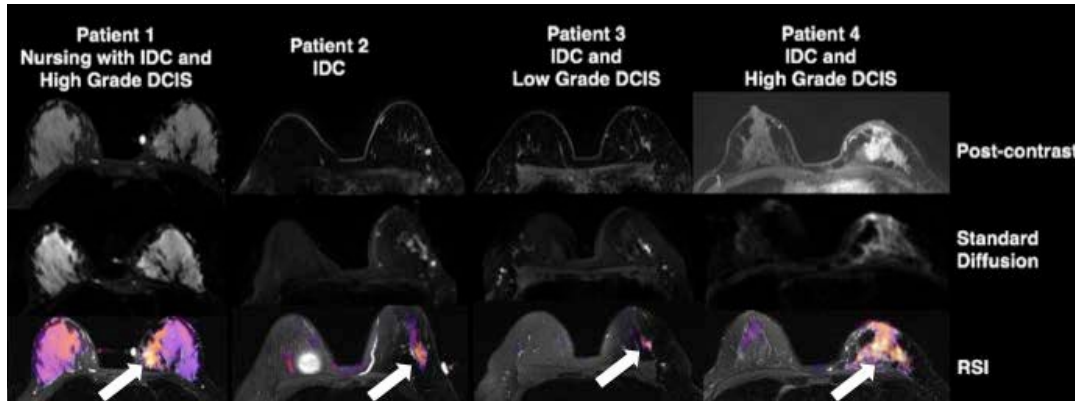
RSI detection of breast cancer. Images from post-contrast MRI, standard DWI, and RSI from 4 of 11 patients are shown. RSI-CI maps show increased tumor conspicuity in all patients in the region corresponding to the biopsy-proven cancer (arrows). Standard DWI identifies the cancer in Patient 2 but not in Patients 1, 3, or 4 (Row 2). Post-contrast MRI detects an 1 x 0.8 x 1.1-cm heterogeneous left breast mass with internal enhancement that correlates with the biopsy-proven cancer in Patient 2 and a 4.6-cm heterogeneously enhancing, spiculated left outer breast mass that correlates with the biopsy-proven cancer in Patient 4 (Row 1). However, post-contrast MRI only shows a minimally enhancing 8.3-cm non-mass enhancement above background in the left breast that corresponds to the area of biopsy-proven cancer in Patient 1 (Row 1; note that this same region in RSI is more conspicuous in Row 3) and fails to detect the cancer in Patient 3. The round white region in the right posterior inner breast on the RSI image in Patient 2 is artifact from the underlying T2-weighted image (Row 3). Data and figure are courtesy of Dr. Rakow-Penner.
